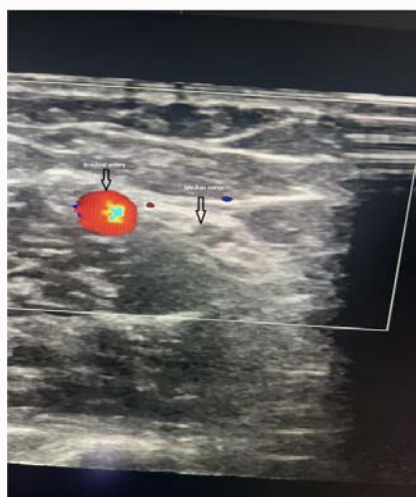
Colour doppler ultrasound view brachial artery with median nerve.
